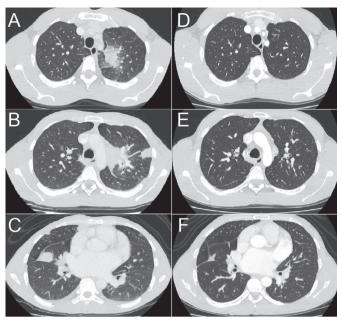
A, B, C: Pre-treatment chest computed tomography (CT) images showing pulmonary masses in the left hilum and adjacent to the right fissure and multiple pulmonary nodules secondary to pulmonary involvement in secondary syphilis. D, E, F: Chest CT images after treatment for syphilis with near total regression of previous lesions.
